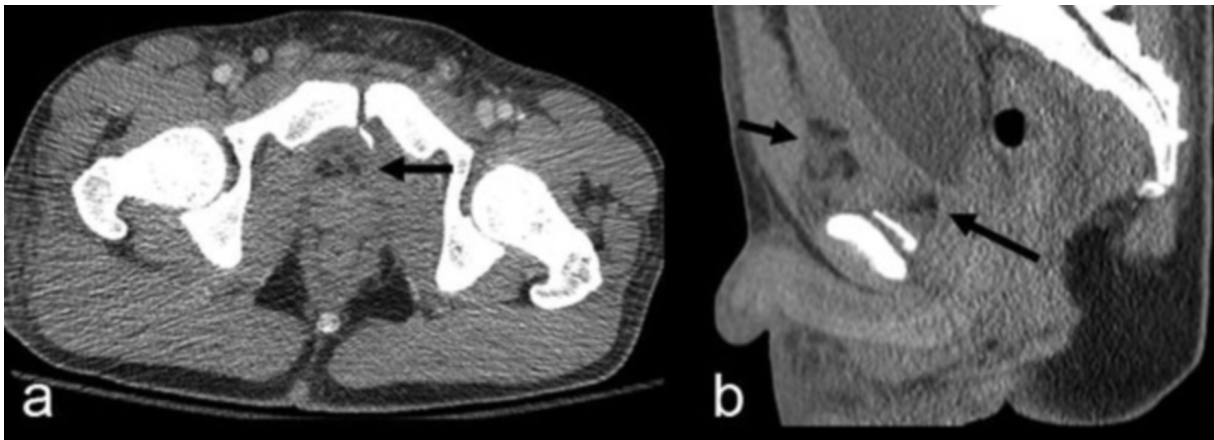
(above). 19-year-old man with levator ani avulsion. CT pelvis in bone window with (a) axial and (b) sagittal views of pelvis demonstrating avulsed fracture of left parasymphysis (arrows), consistent with levator ani muscle avulsion.
